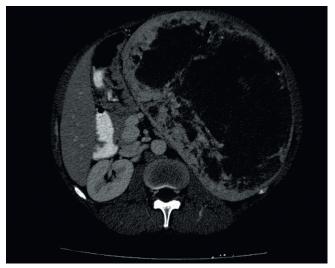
Contrast-enhanced computed tomography scan of the abdomen revealing an enlarged spleen with solid components and hypodense cystic areas consistent with peliosis.
